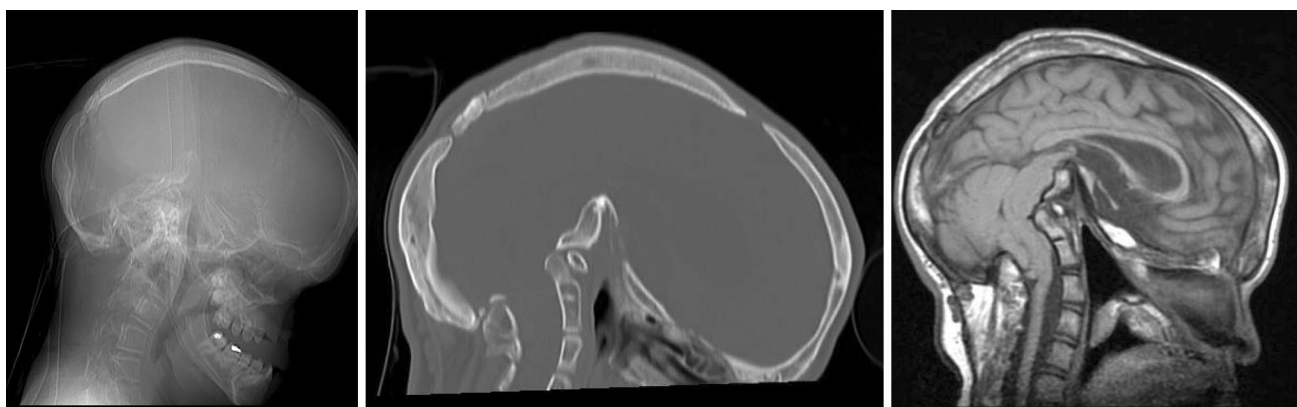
Lateral CT scout view (left), sagittal CT scan (center) and sagittal FSE T1 MRI image showing basilar invagination. The lambdoid suture remains closed. Wormian bones are visible within the suture
